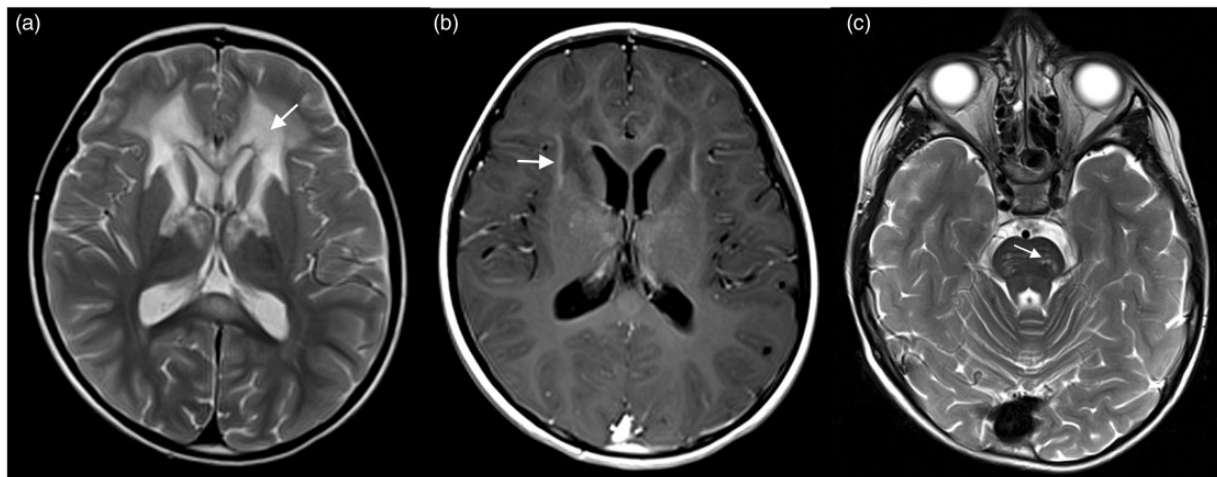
T2-weighted (a, c) and T1-weighted (b) MR images showing the “cerebral inflammatory phenotype” of X-ALD with severe, symmetric demyelination of the frontal WM (a, arrow). Diverging signal intensities in (a) and contrast enhancement in (b, arrow) indicate different activity of demyelination. Symmetric involvement of the long fiber tracts is common in X-ALD (c, arrow). 1.5 T Siemens Aera (Siemens Medical Systems, Erlangen, Germany).
